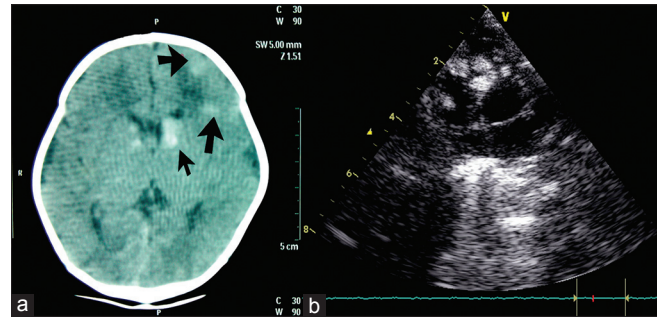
Apical four chamber view of two-dimensional echocardiogram showing multiple rhabdomyomas of heart in the mid and apical interventricular septum (a). Multiple subependymal nodules and cortical tubers (shown by black arrows) in computed tomography scan of brain (b)
